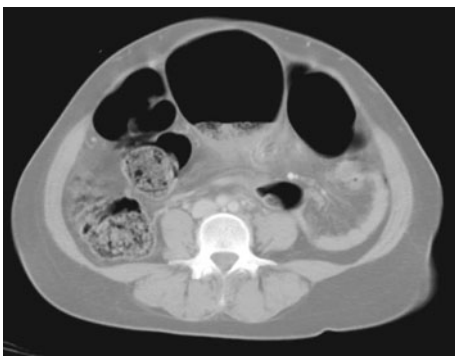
Axial abdominal CT image of sigmoid volvulus (dilated sigmoid colon with whirl pattern in mesentery)
